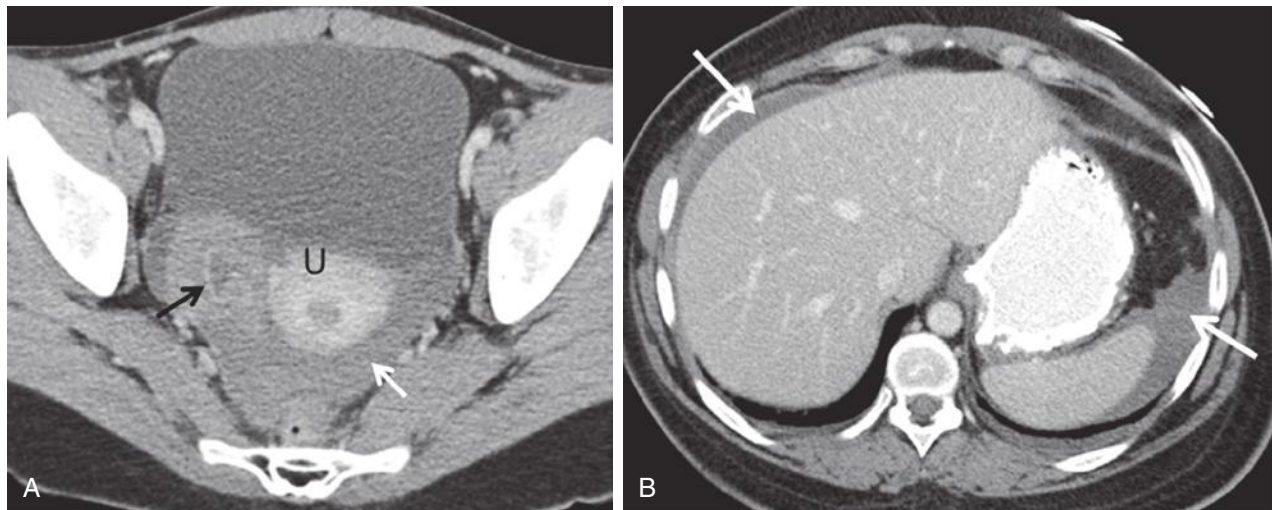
Ruptured hemorrhagic cyst at contrast-enhanced computed tomography (CT). A, An irregular, crenulated rim-enhancing cyst (*black arrow*) is visible in the right adnexa surrounded by a high attenuation blood clot. High attenuation fluid compatible with blood (*white arrow*) is present in the cul-de-sac posterior to the uterus (U). B, More superior CT image demonstrates blood in the upper abdomen adjacent to the liver and spleen (*arrows*).
